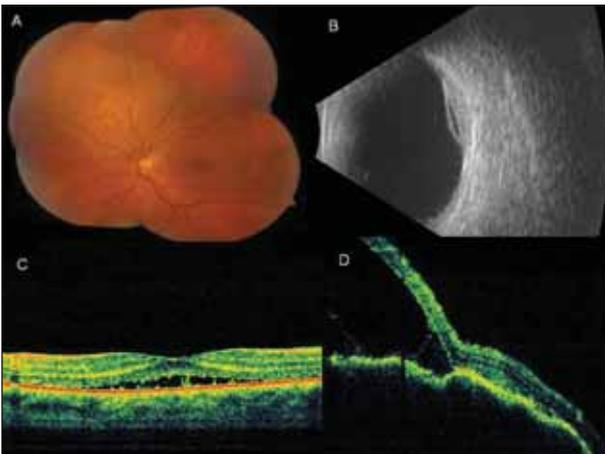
A 65-year-old white woman with blurred vision manifested choroidal metastasis from primary breast carcinoma. The amelanotic choroidal metastasis measured 12 mm in diameter (A). Ultrasonography confirmed 2.6 mm in thickness and shallow overlying subretinal fluid (B). Optical coherence tomography depicted the subtle subfoveal fluid (C). Optical coherence tomography over the tumor showed the irregular surface of the metastasis and thinned detached retina (D).
